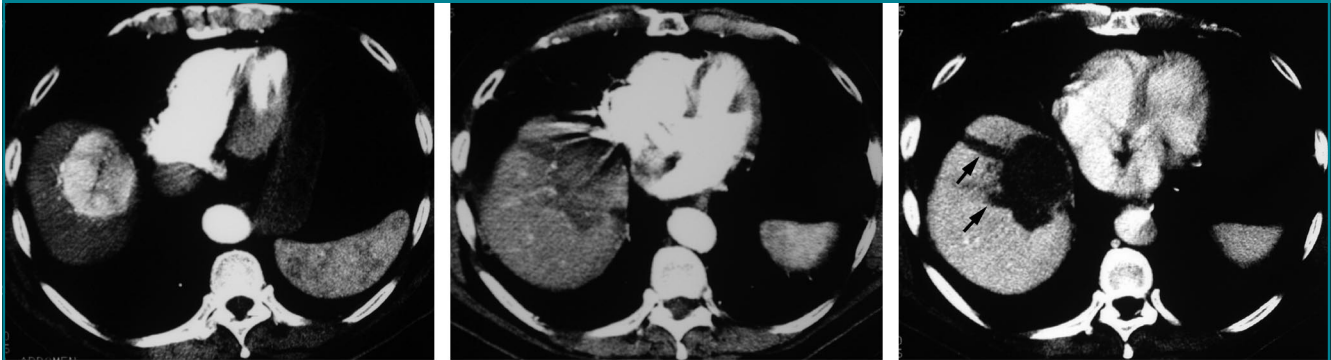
Transverse CT scans show complete ablation of large HCC in 63-year-old man with Child-Pugh class A cirrhosis related to viral hepatitis C. (a) Before treatment, scan obtained in arterial phase shows 5.2-cm subdiaphragmatic hypervascular mass in segment VIII of the liver. (b) One month after multipolar RF ablation consisting of one procedure, including two applications (total amount of RF energy delivered, 240 kJ), scan obtained in arterial phase shows absence of tumor enhancement consistent with complete ablation. (c) On scan obtained during the portal phase of the same CT study at which b was obtained, the mass remains unenhanced. Note also the ablated electrode tracks (arrows).
